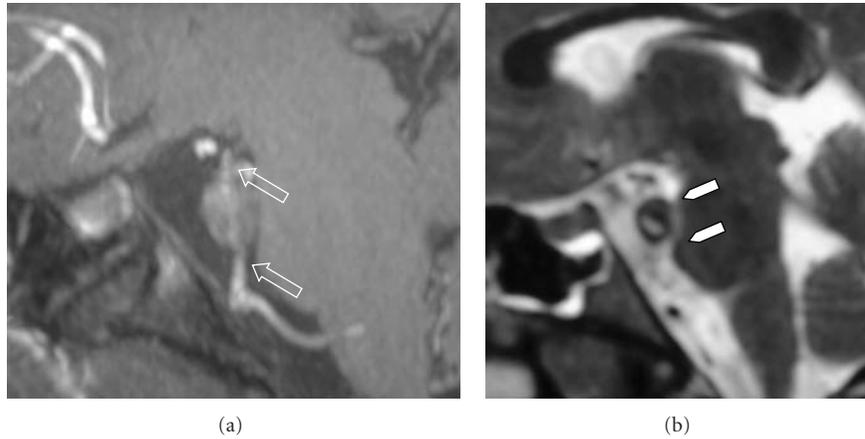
MRA (a) and MRI sagittal sections (b), obtained 11 days after the initial symptoms, demonstrate the presence of a BA aneurysm with mass effect on the pons (arrowheads in (b)) and ischemic changes (not shown). At both edges of the aneurysm, stenosis of the BA is recognizable (arrows in (a)).
